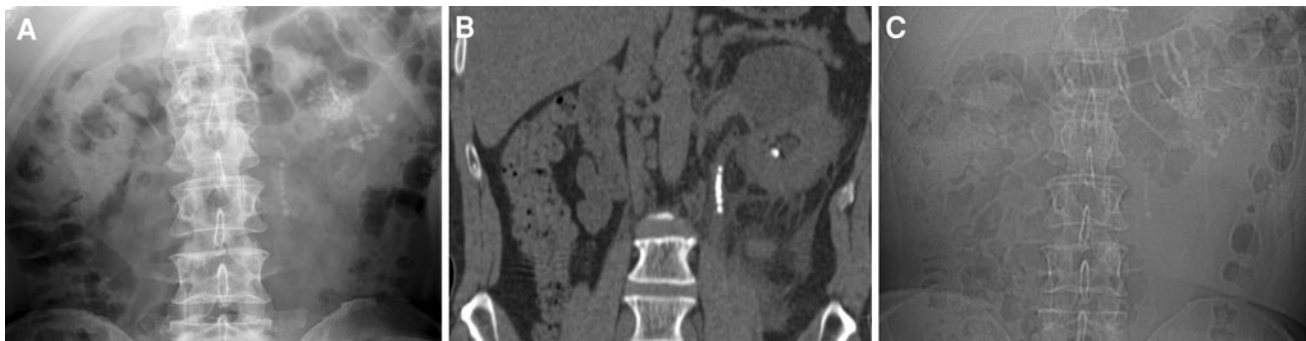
Multiple kidney stones seen in left kidney and proximal ureter. a KUB b CT coronal reconstruction and c CTI
